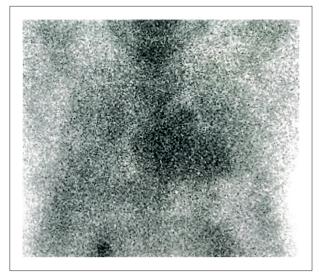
Myocardial scintigraphy image with pyrophosphate-99mTc with Perugini 3 uptake.
